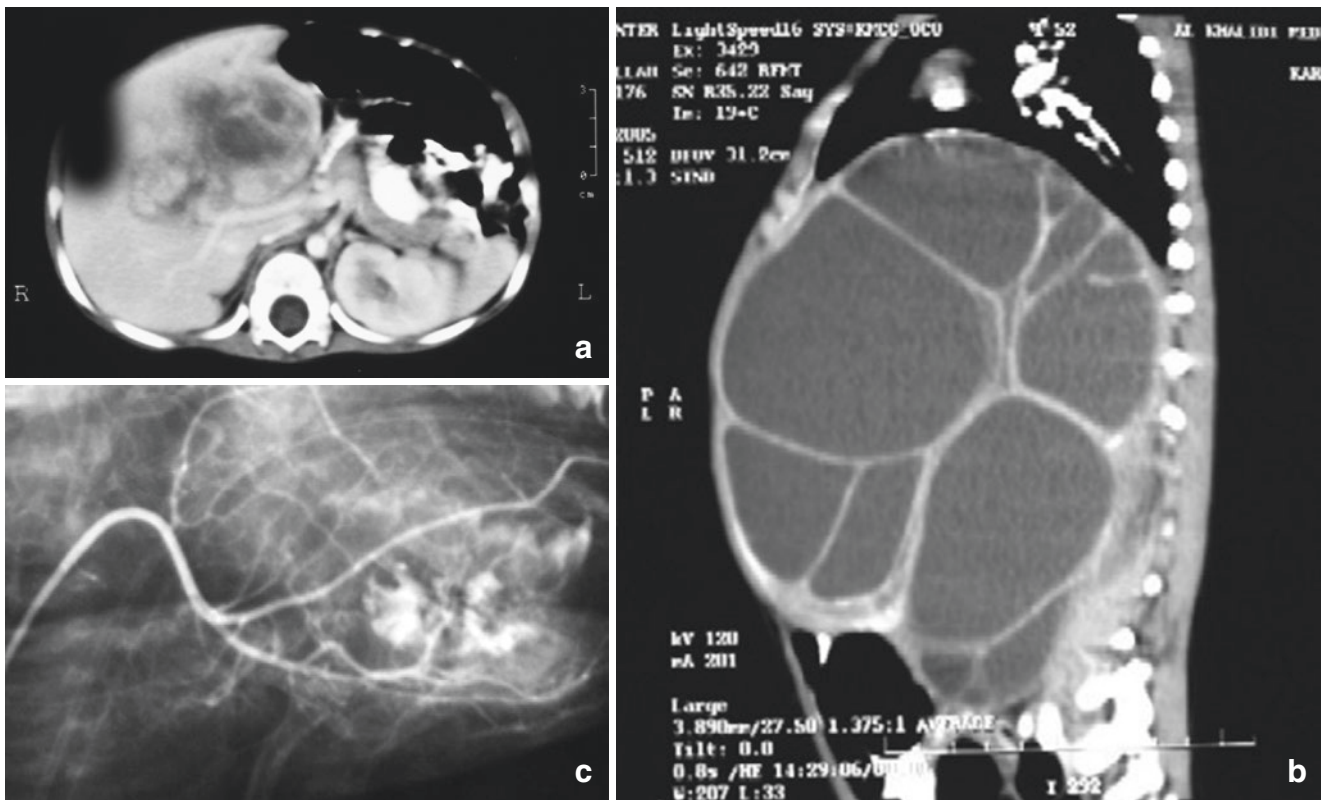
(a) CT scan showing a hepatic hamartoma. (b) CT scan of a hepatic hamartoma with multiple cysts. (c) Hepatic hamartoma, multiple cysts, angiogram
